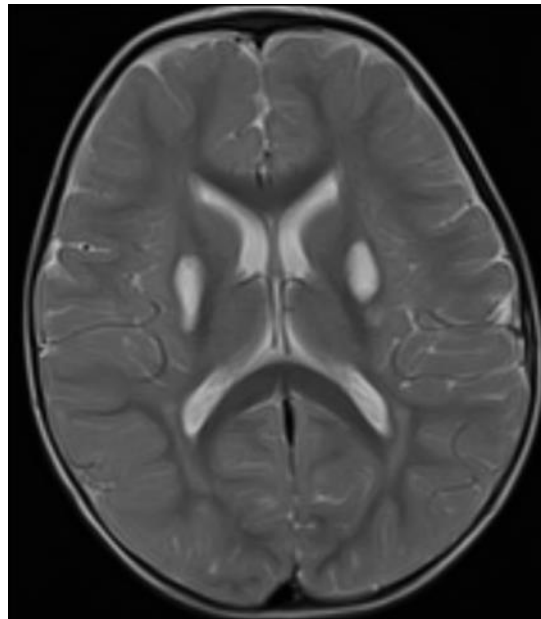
MRI, axial T2 sequence: hyperintensity in putamen, in mtND3 case
